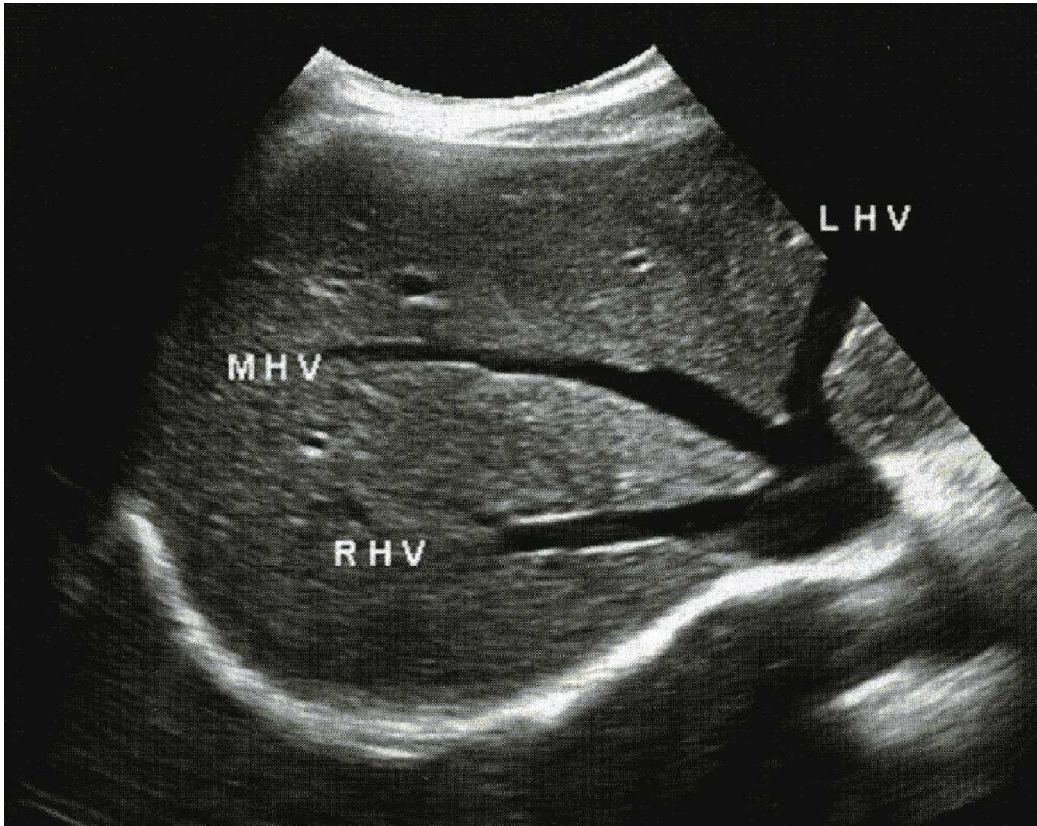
ultrasound image of hepatic veins. (Rumak et, al2005)
